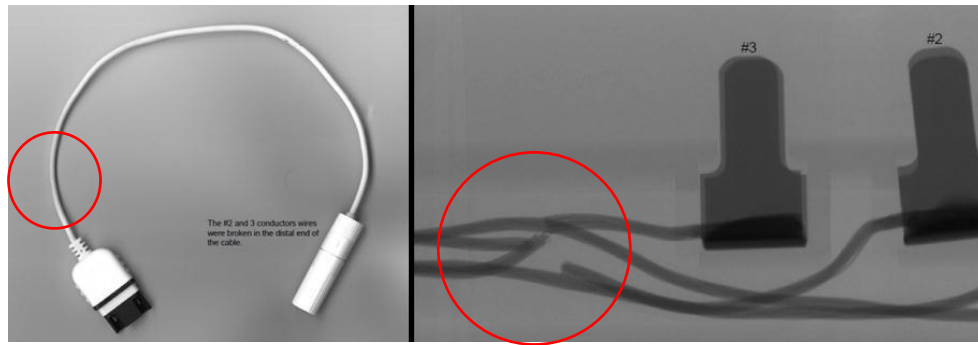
X-ray confirming extension lead fractures through flexing
